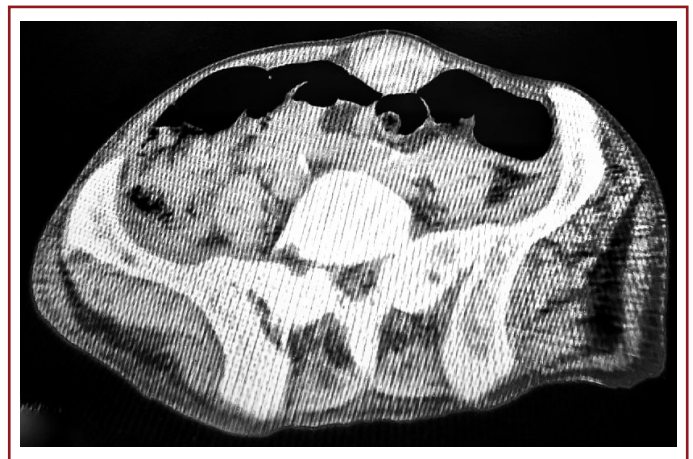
CT scan showing RSH, 4 cm in diameter, in the right lower quadrant.
